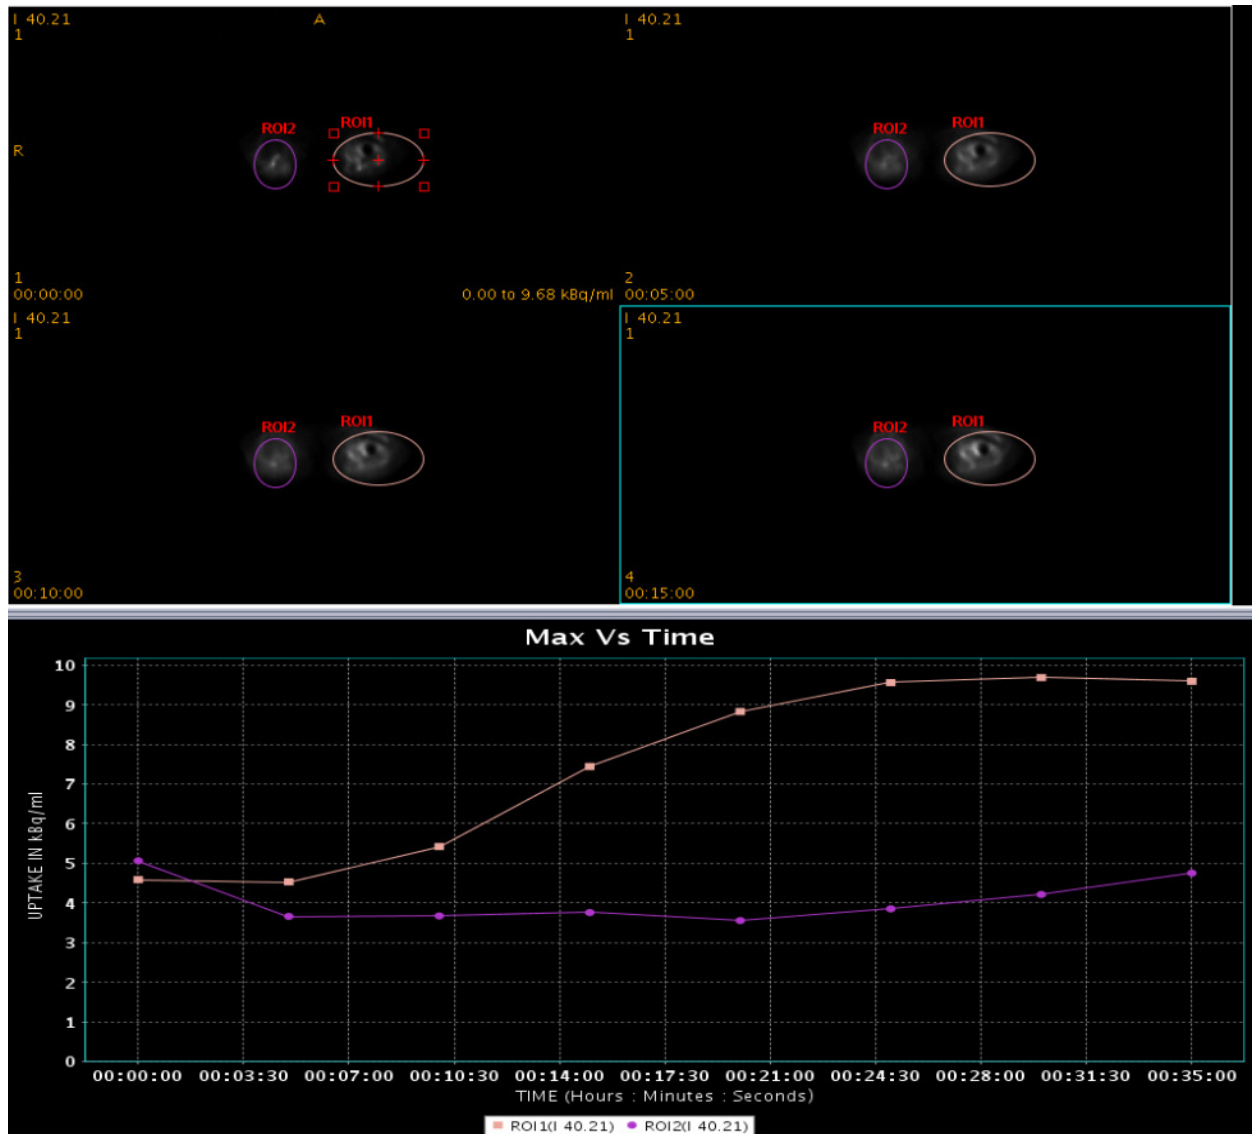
NaF SUV vs sec. Symptomatic knee (pink) & asymptomatic knee (purple)
